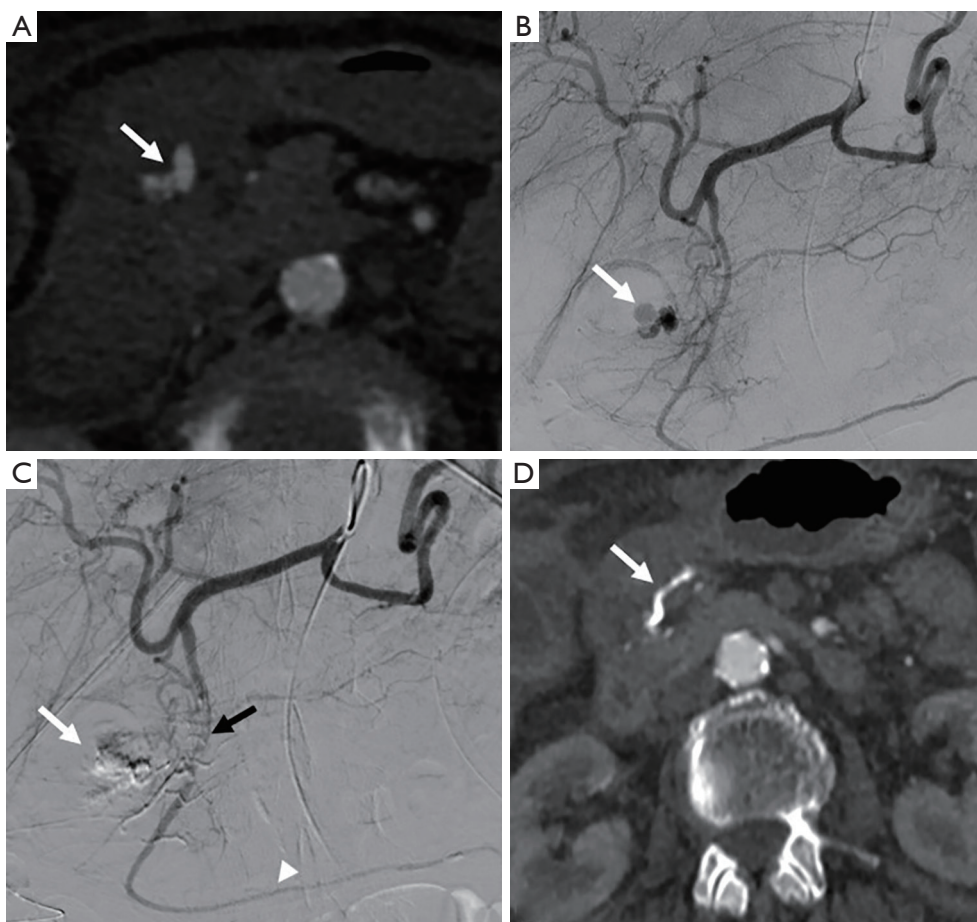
A 78-year-old female patient presenting with hematemesis in a context of perforated gastric ulcer treated by surgical suture. Patient had persistent hematemesis after surgery. (A) Abdominal CT angiogram showing a VAPA in the lumen of the second duodenum, with active bleeding (arrow). (B) Angiogram showing irregular VAPA arising from a branch of gastroduodenal artery (arrow). (C) Control angiogram after TAE with 1 mL NBCA/lipiodol mixture (ratio 1:1) showing no more filling of the pseudoaneurysm (white arrow), patency of gastroduodenal artery (black arrow) and right gastroepiploic artery (arrowhead). (D) Control CT scan at one day post-operation showing no more filling of the VAPA (arrow). CT, computed tomography; VAPA, visceral artery pseudoaneurysm; TAE, transarterial embolization; NBCA, N-butyl-2-cyanoacrylate.
